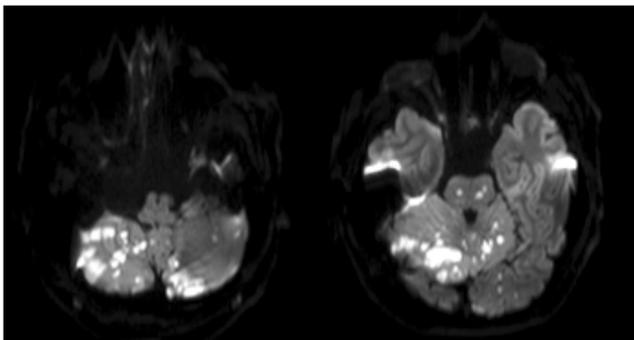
Brain magnetic resonance imaging with diffusion weighed imaging (DWI) sequence showing multiple ischemic lesions involving both cerebellar hemispheres and pons due to embolization from a cardiac myxoma
